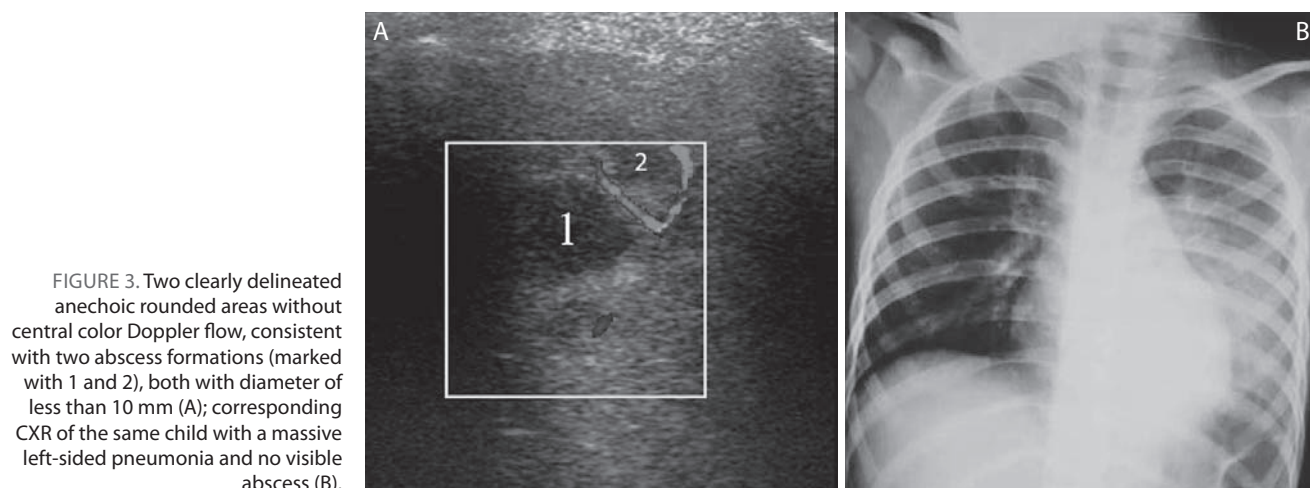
Two clearly delineated anechoic rounded areas without central color Doppler flow, consistent with two abscess formations (marked with 1 and 2), both with diameter of less than 10 mm (A); corresponding CXR of the same child with a massive left-sided pneumonia and no visible abscess (B).
